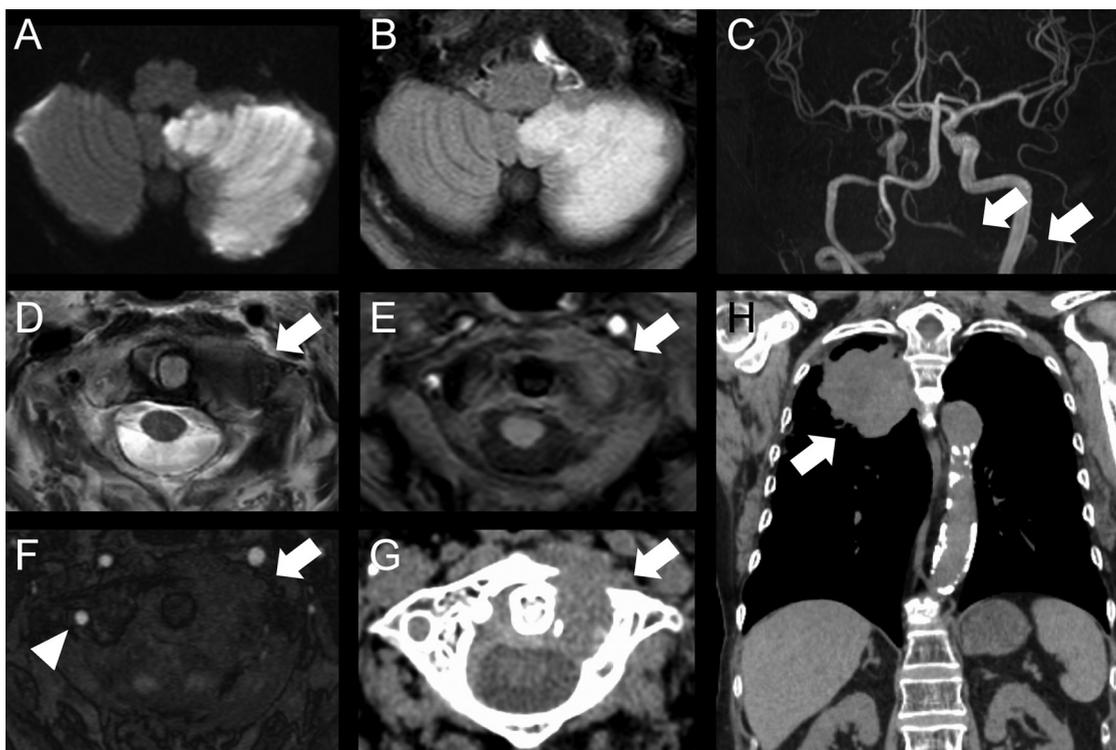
Figure (A) Diffusion-weighted and (B) fluid-attenuated inversion recovery images show high signal intensity in the left cerebellum of the left posterior inferior cerebellar artery territory. (C) Brain magnetic resonance angiography shows that the signal intensity of the left vertebral artery is severely reduced (arrows). (D) Brain T2-weighted and (E) T1-weighted images at the bottom slice show abnormal intensity of the left C1 vertebra (arrows). (F) Magnetic resonance angiography source images also show a mass at the left C1 (arrows). The arrowhead shows the right vertebral artery. (G) Neck computed tomography shows destruction of the left C1 vertebra by the mass (arrow). (H) Chest computed tomography shows right lung mass (arrow).
